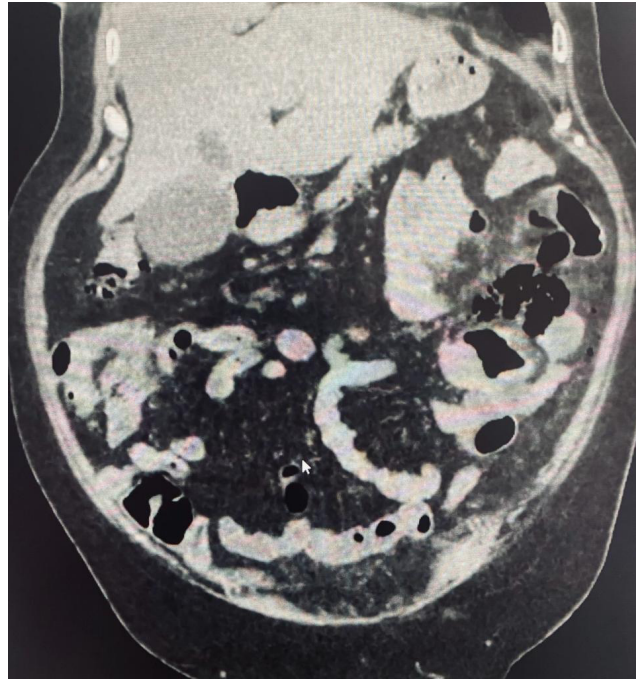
Coronal abdominal CT revealing multiple jejunal diverticula.
